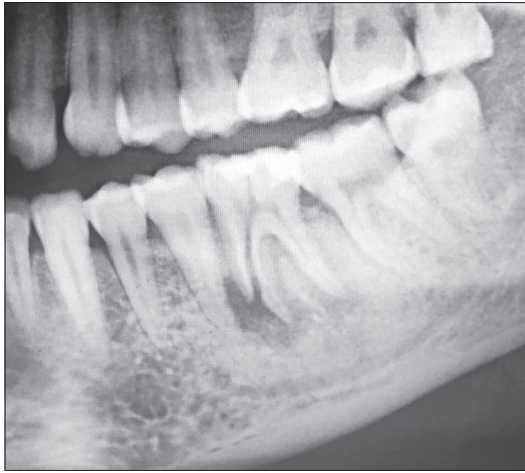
Pre-treatment radiograph indicating split tooth #19 and significant infection around its mesial root and distal root surface of tooth #20
